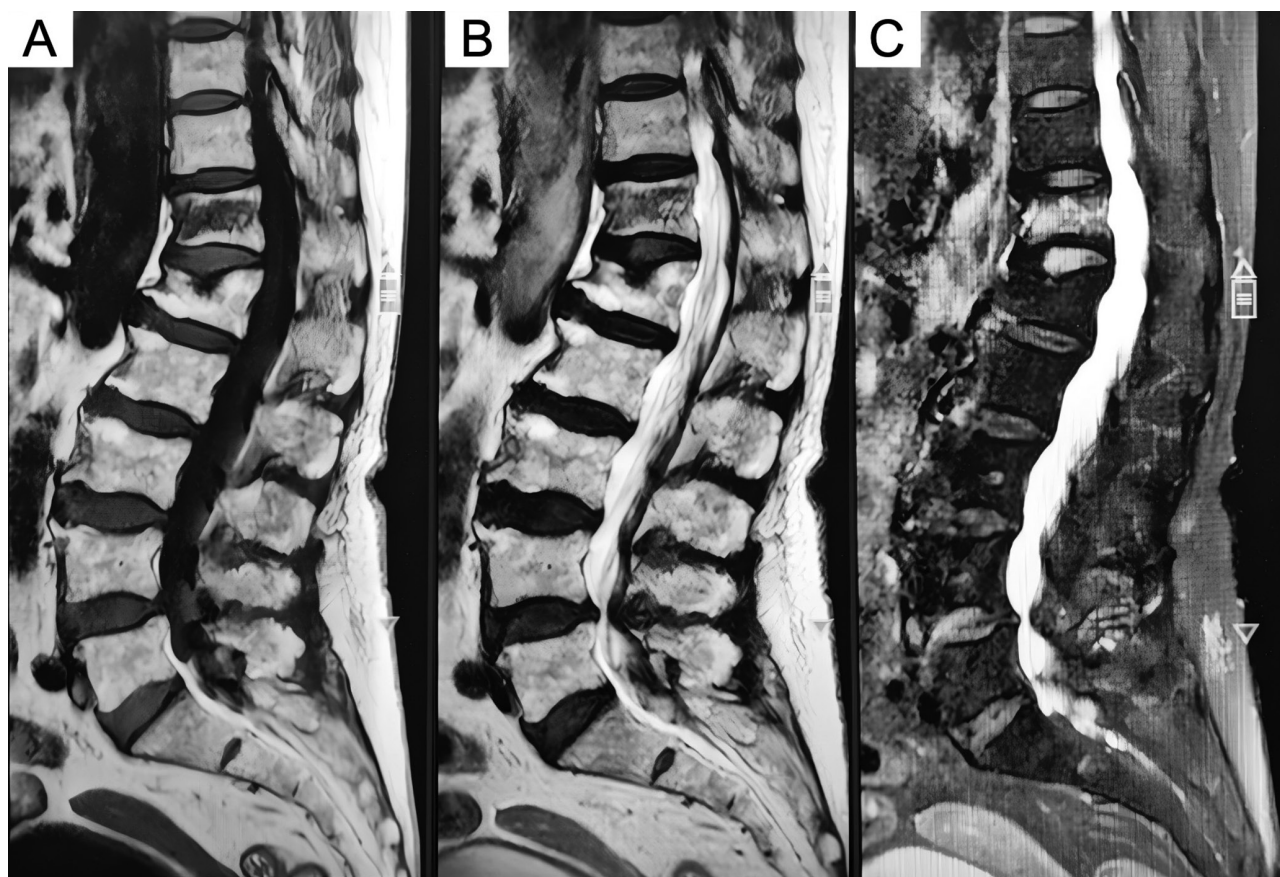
Typical case: preoperative lumbar magnetic resonance imaging. T1 (A) and T2 (B) sequences indicate a compression fracture of the thoracic vertebra 12, an intravertebral bar fracture signal shadow, and a high signal shadow indicative of an evident fracture of pressure fat (C), suggesting vertebral intramedullary edema and confirming a fresh T12 fracture.
